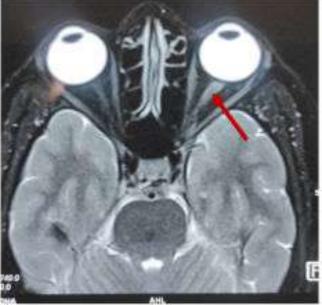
MRI orbit (axial view) showing left optic nerve thickening and enhancement
